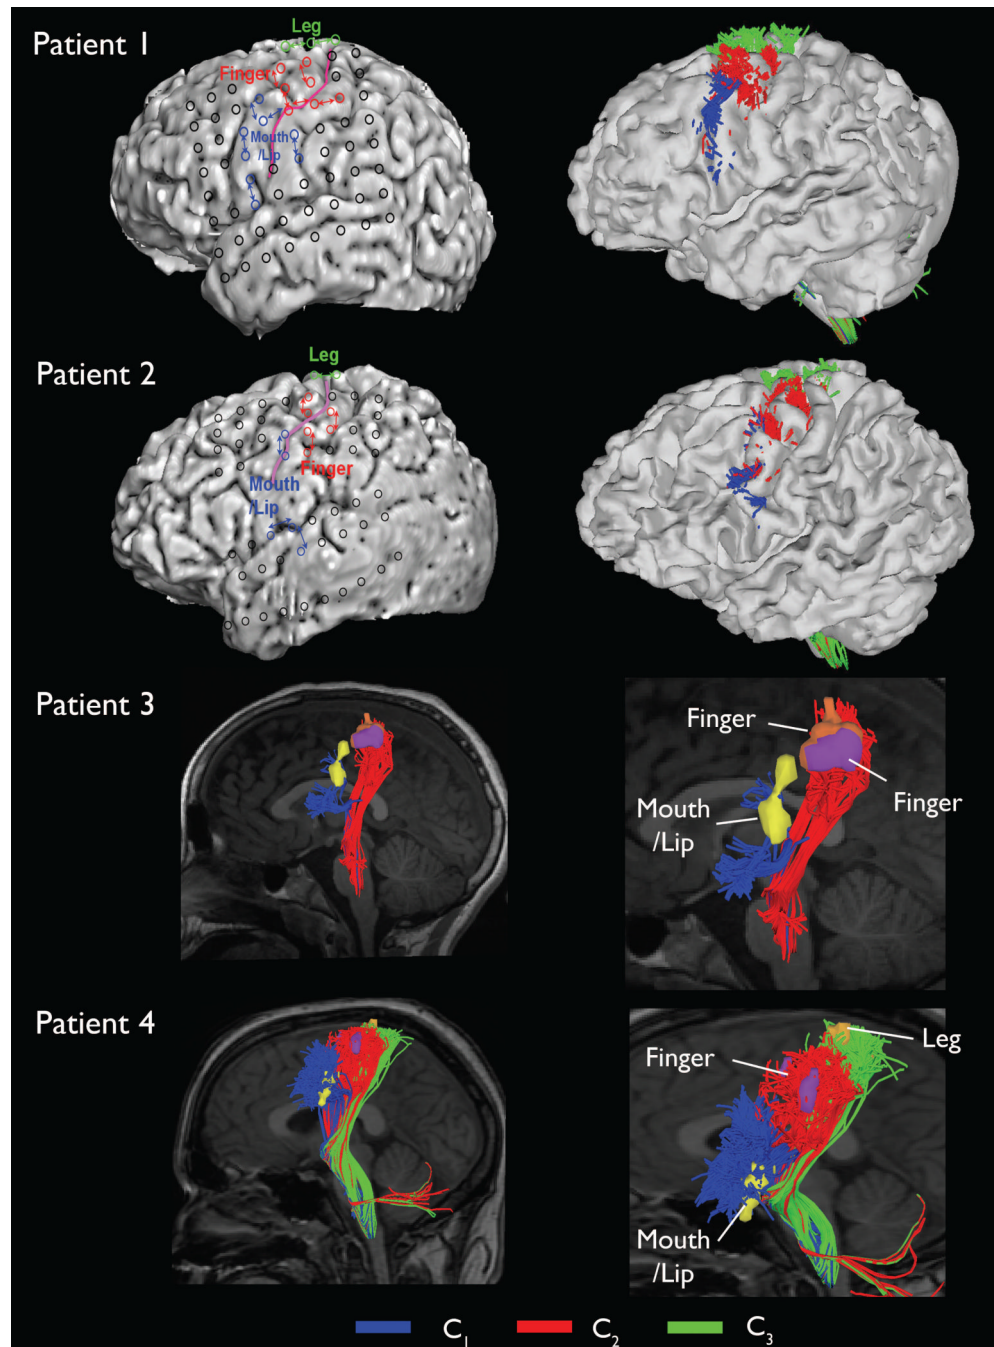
Automatic detection of primary motor pathways using DWI-MAP classifier obtained from four patients with focal epilepsy. Black circles on the three dimensional brain surface represent the locations of electrodes used for ESM. C₁: 'mouth/lip pathway', C₂: 'finger pathway', C₃: 'leg pathway' were obtained using the DWI-MAP classifier.
